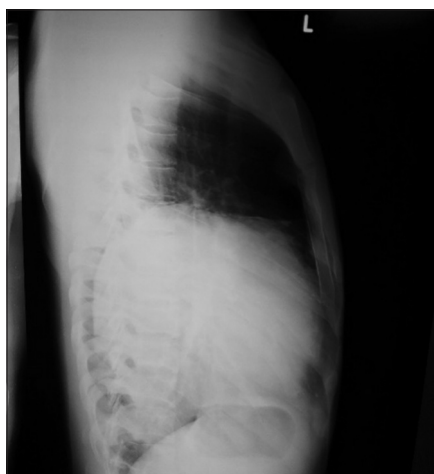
Chest X-ray left lateral showing a mass lesion in left lower lobe
